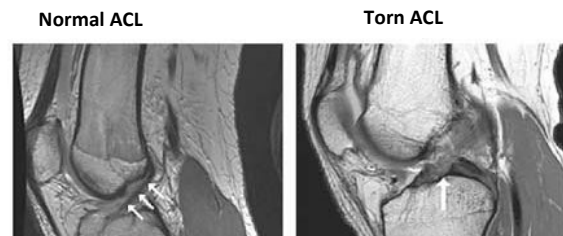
MRI of ACL in the knee.
